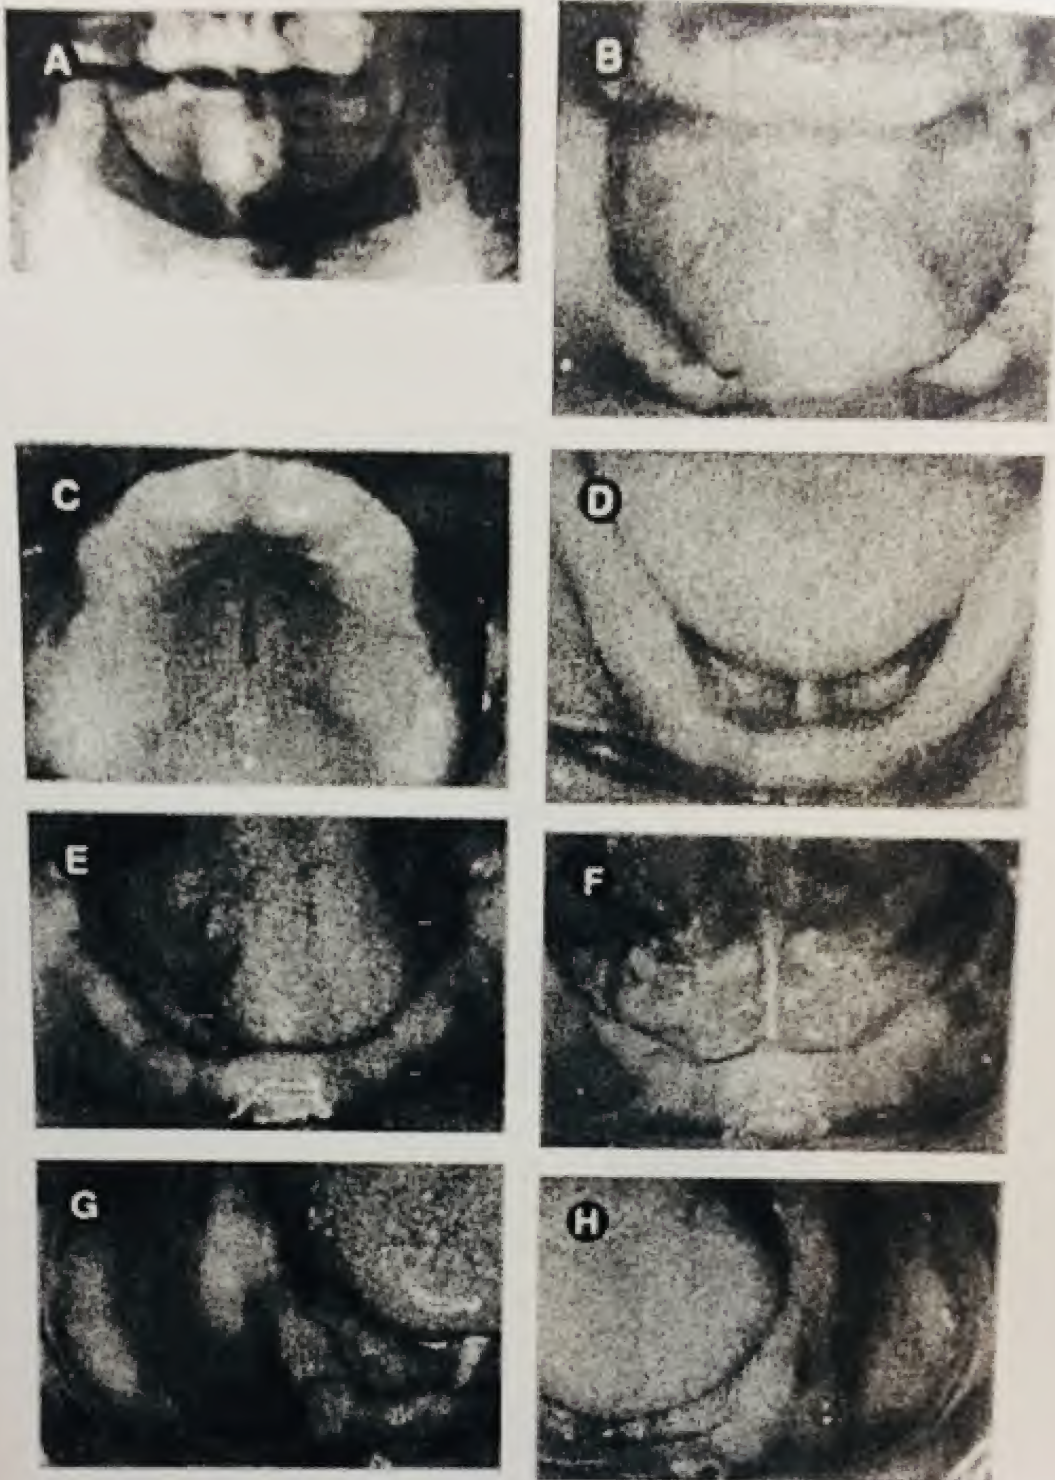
Class II patient. (A) Panoramic radiograph. (B) Facial view at the approximate occlusal vertical dimension. (C) Occlusal view: maxillary arch. (D) Occlusal view: mandibular arch. (E) Facial view: tongue in resting position. (F) Facial view: tongue elevated. (G) Lateral view of mandible: patient right. (H) Lateral view of mandible: patient left.
